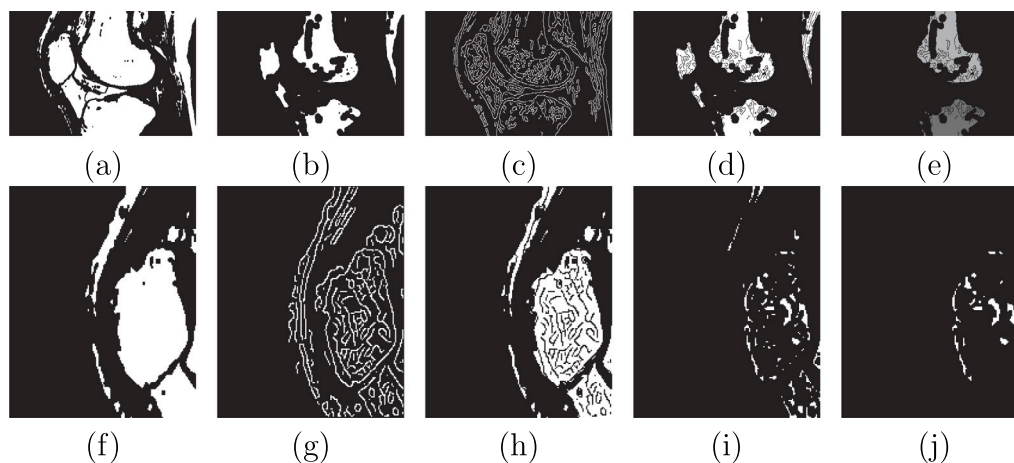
Segmentation of the pre-processed MR image shown in Fig. 2(d): tibia and femur from (a) to (e), patella from (f) to (j), where (a) initial thresholding; (b) erosion; (c) image edges; (d) elimination of the edges (c) from the eroded mask (b); (e) three 3D connected components having larger volumes (the third one does not appear in the shown slice); (f) subvolume for searching the patella; (g) edges in the subvolume; (h) elimination of the edges; (i) erosion; (j) the connected component of (d) having maximum volume.
